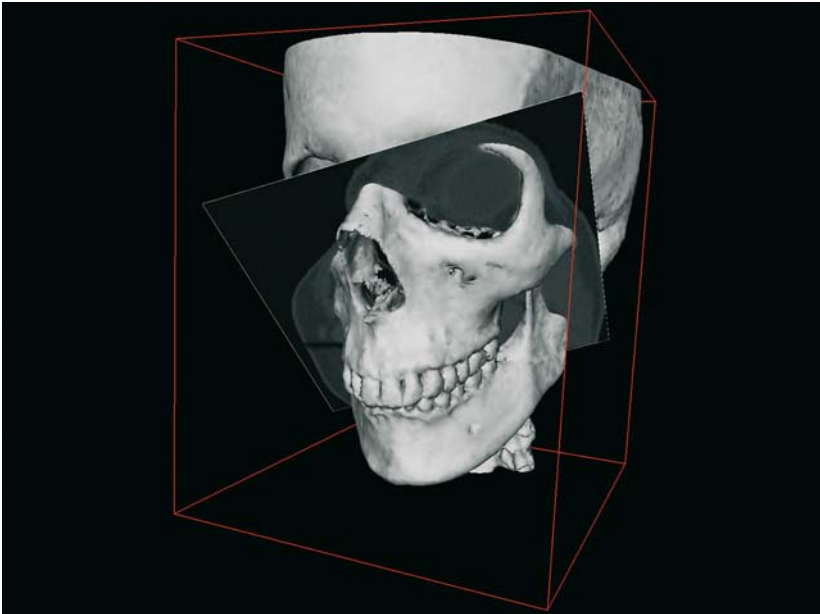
By computing the CT numbers at the intersection of a rectangle with the image volume, any reslice can be defined
